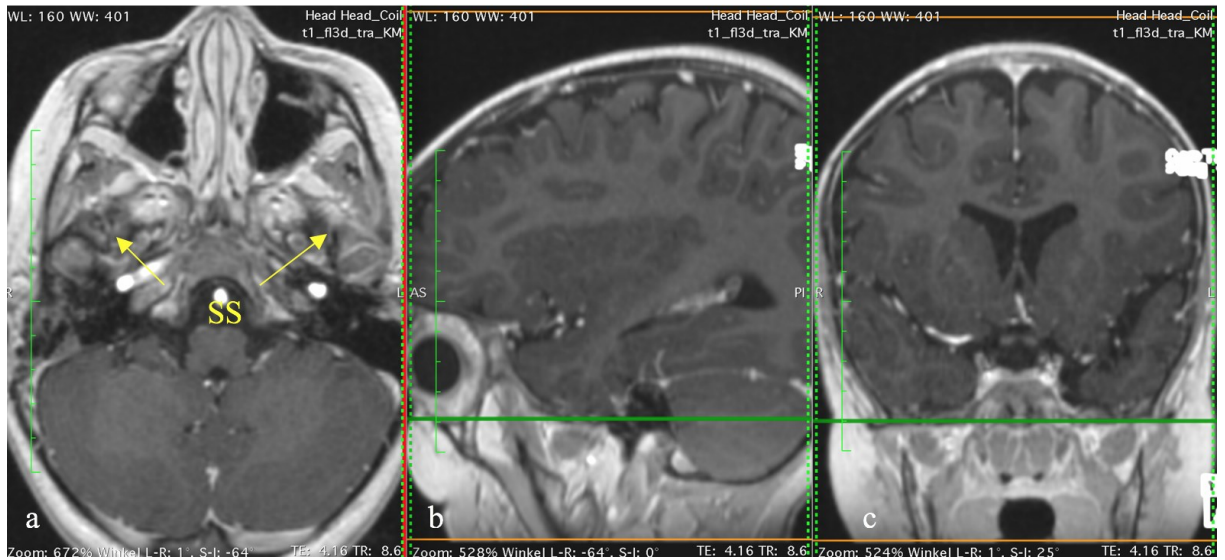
MRI of a pediatric skull of a 4 years old female showing the sphenosquamous sutures (yellow arrows) in a axial view, b sagittal (right sphenosquamous suture) and coronal reformat.
